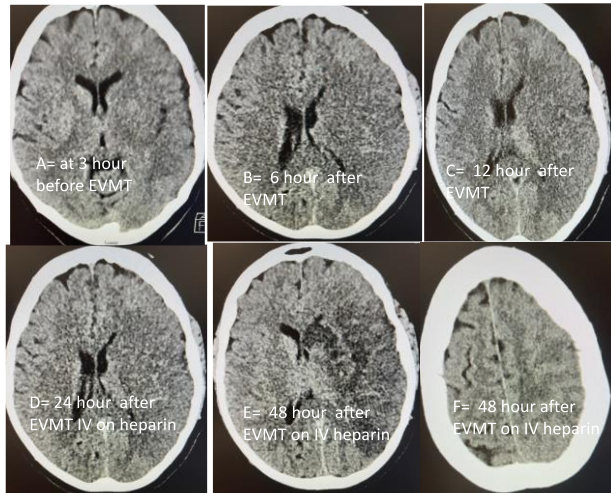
Initial ASPECT 5 at presentation and, 6, 12, 24 and 48 hours after EVMT
